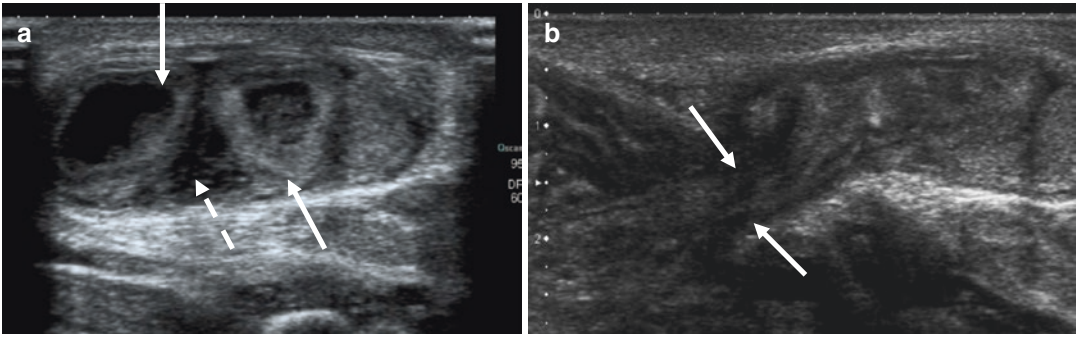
Complicated right inguinal hernia a 22-month-old boy with abdominal pain and vomiting. After a first unsuccessful attempt to reduce the hernia, the surgeon asked for an ultrasound. (a) Axial image of the inguinal
